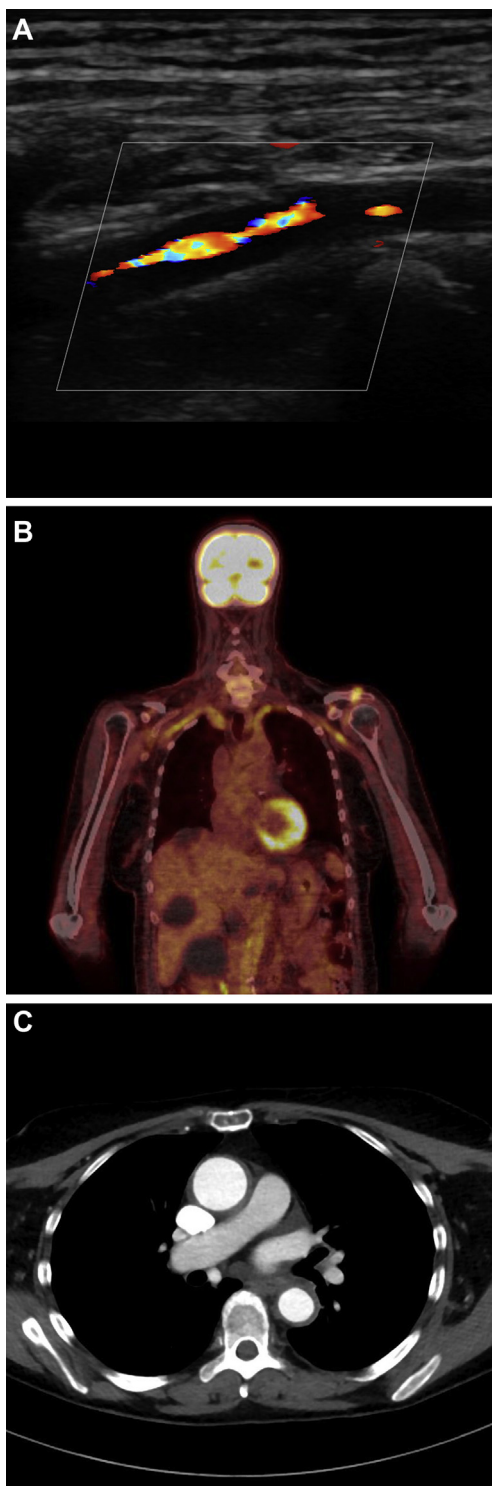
A, Duplex ultrasound image of the axillary artery in the longitudinal view demonstrating a hypoechoic circumferential vessel wall edema (halo sign) with consecutive subtotal stenosis. B, Coronal reconstruction of the ^{18}F -fluorodeoxyglucose positron emission tomography-computed tomography scan demonstrating increased tracer uptake in the subclavian and axillary arteries. C, Computed tomography angiography displaying vessel wall thickening of the ascending and descending thoracic aorta.
